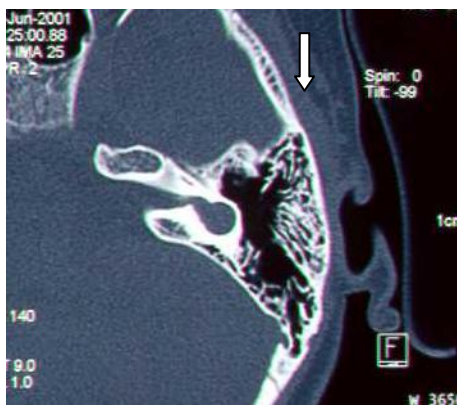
Patient 10a: transversal CT-image, left ear; common cavity, aplastic semicircular canals.
